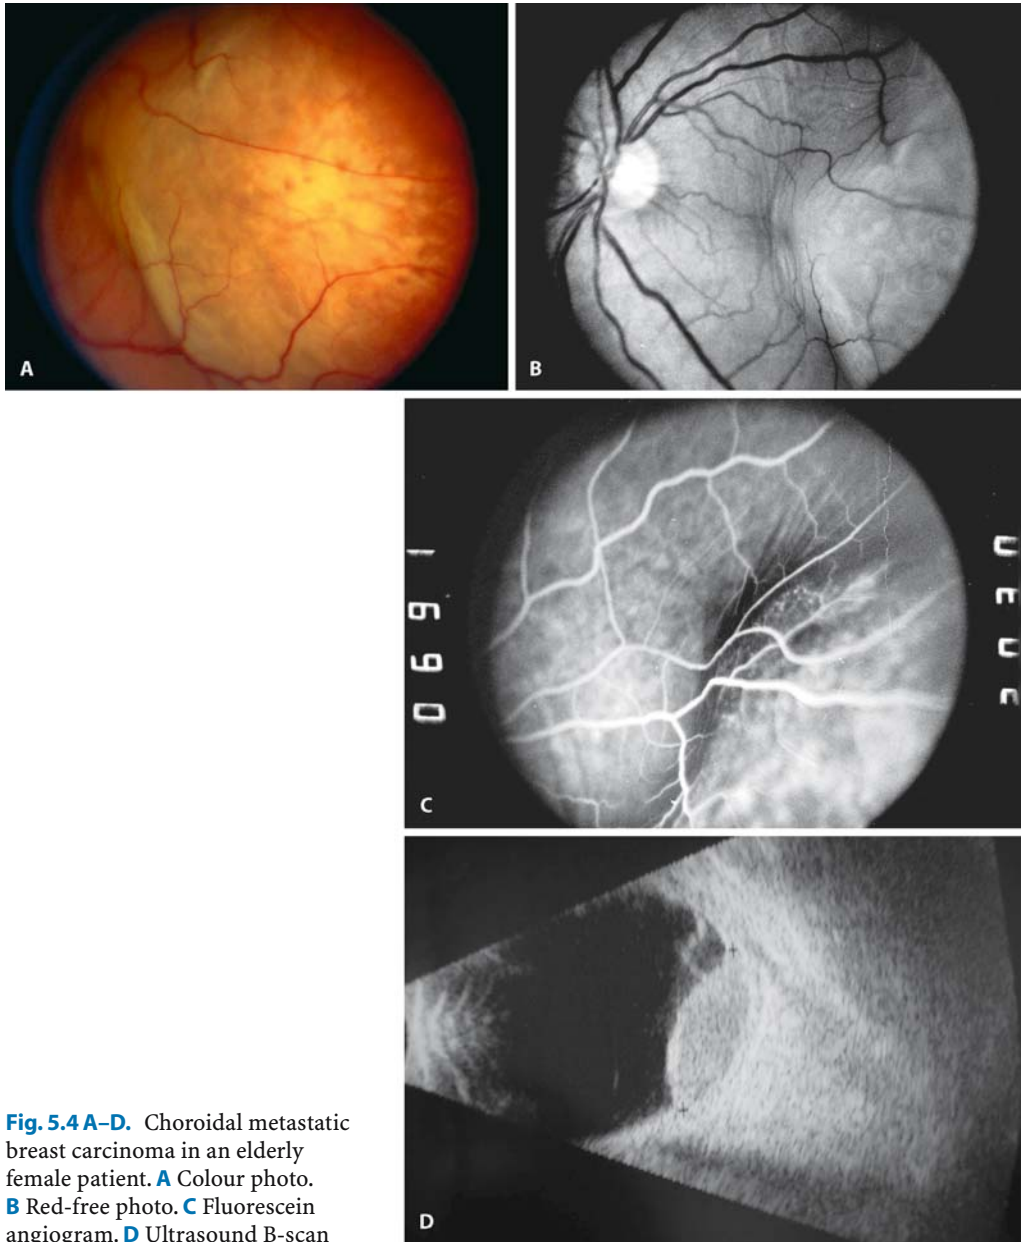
A–D. Choroidal metastatic breast carcinoma in an elderly female patient. A Colour photo. B Red-free photo. C Fluorescein angiogram. D Ultrasound B-scan
